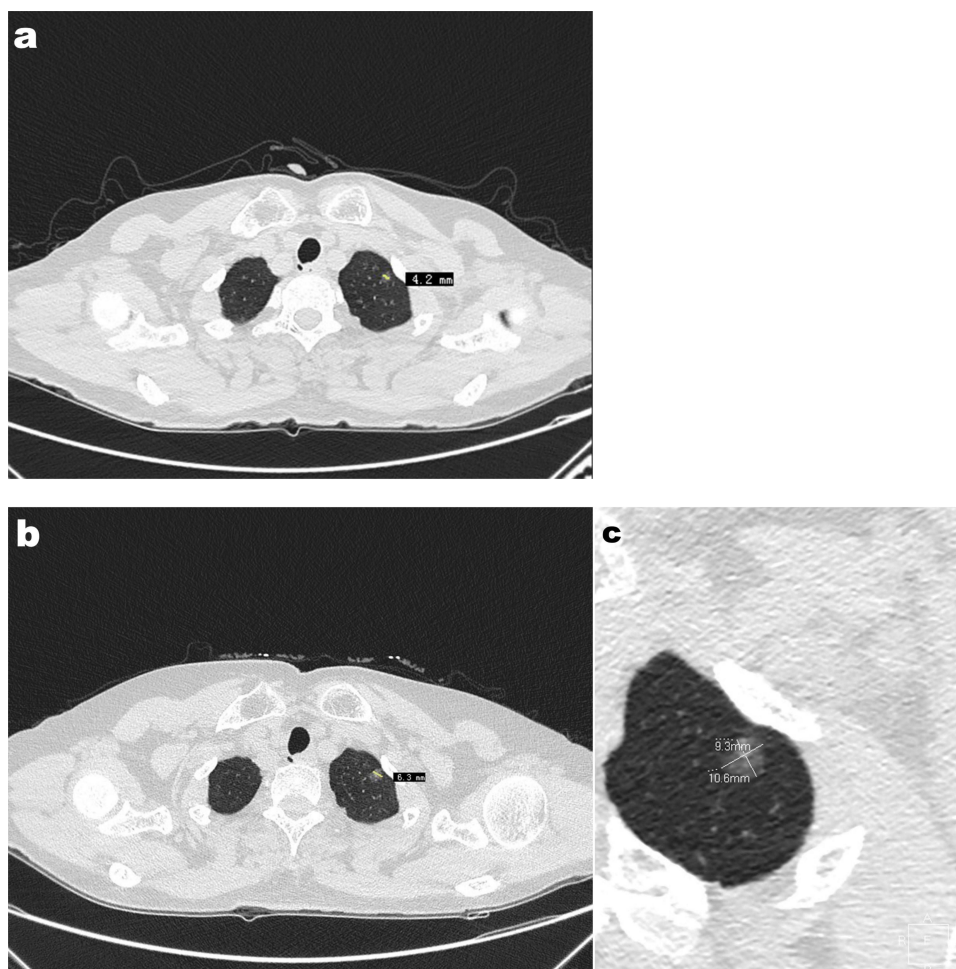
Computed tomography(CT) images: (a) Chest CT scan showed a ground-glass nodule(4.2mm) in the upper lobe of the left lung; (b and c) The nodule was progressively enlarged during the follow-up two years(6.3mm to 9.3mm).
